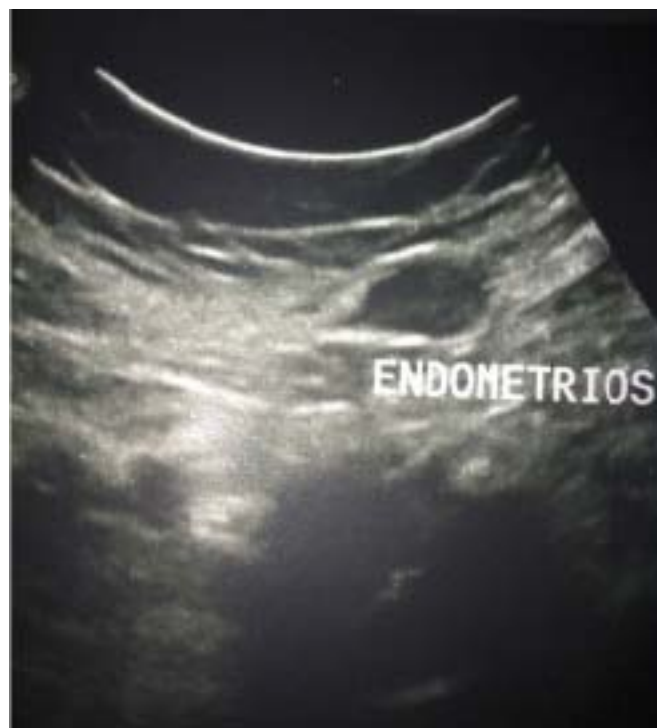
Abdominal ultrasonographic examination demonstrates endometriotic implant located 3 cm below umbilicus laterally
